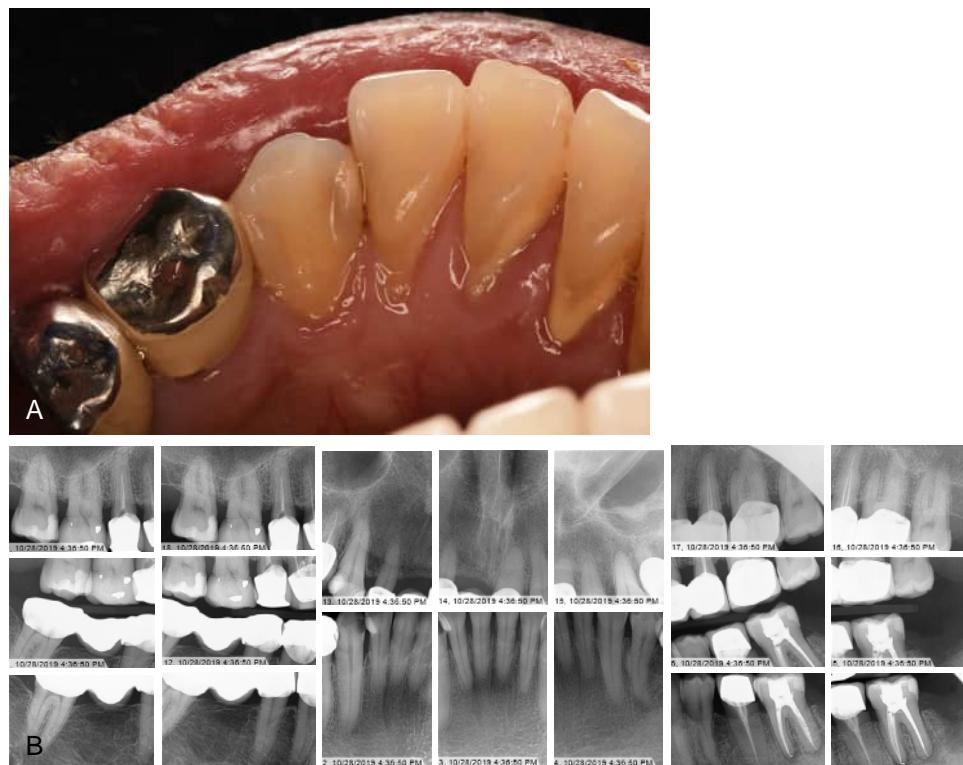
(A) Clinical presentation of a Stage I periodontitis case. This patient presented with 1-2 mm of interdental clinical attachment loss at the site of greatest loss and a maximum probing depths of 4 mm. Note the heavy buildup of supragingival calculus and the overt gingival inflammation. (B) Radiographic presentation. These are the radiographs of the same patient case pictured in Fig. 15-1(A). Along with the clinical presentation of the soft tissue, radiographs show mostly horizontal bone loss extending to the coronal one-third of the root length, which is consistent with Stage I periodontitis.
